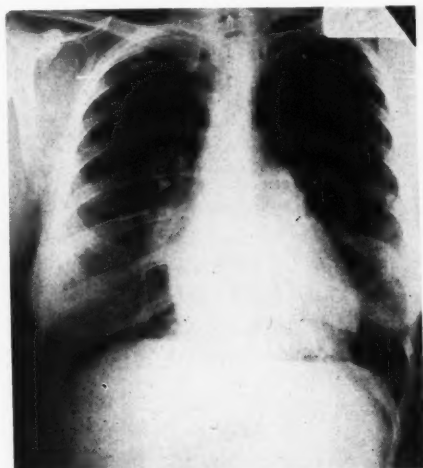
Case 2. (A. F.) Preoperative chest roentgenogram, P-A view. There is slight cardiac enlargement, prominence of the pulmonic segment, increased hilar markings, left auricular enlargement and calcification in the region of the mitral valve.
